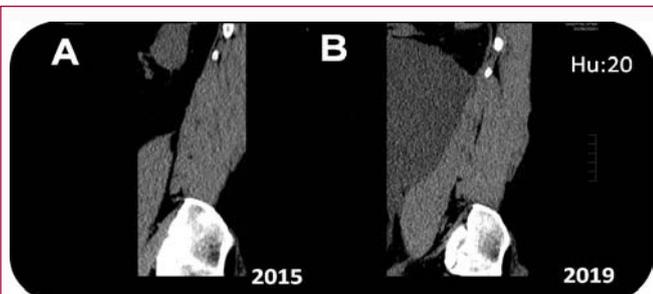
CT lumbar scan performed January 2020, which showed small disc herniation at L4-L5. However, CT scan also incidentally identified a low density (HU: 20) mass involving the left retroperitoneum. The mass was not present on the previous scan from 2015.
